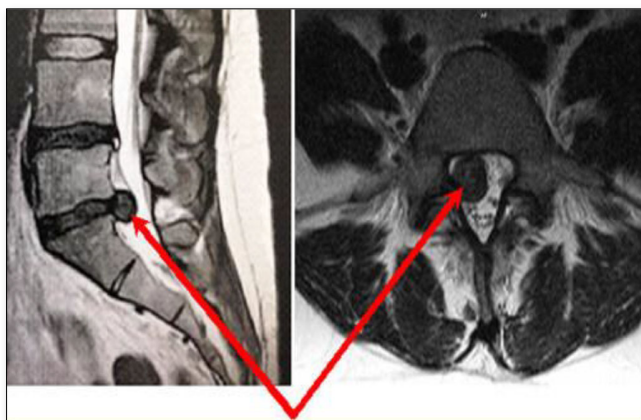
Lumbar MRI: herniated disc L5 S1 right.
